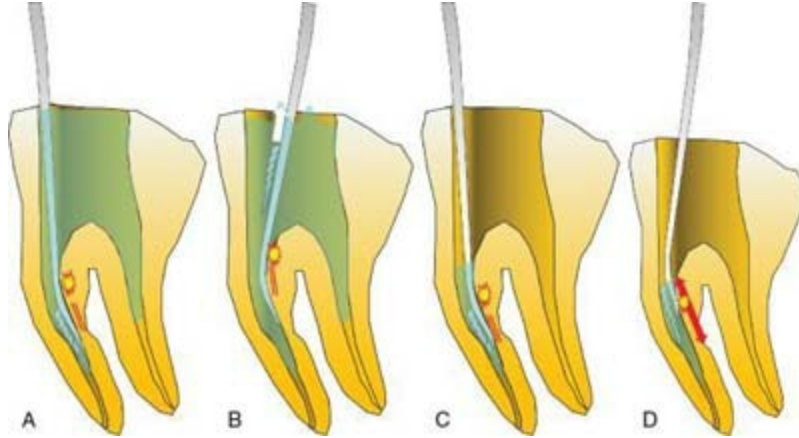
A, Fluid filled in the canal and the pulp chamber. B, Separated file is coming out of the canal to the pulp chamber in the fluid with ultrasonics (*white arrow*). C, Fluid filled only in the canal. D, Separated file fluctuating within the canal space filled with fluid (*red arrows*).
